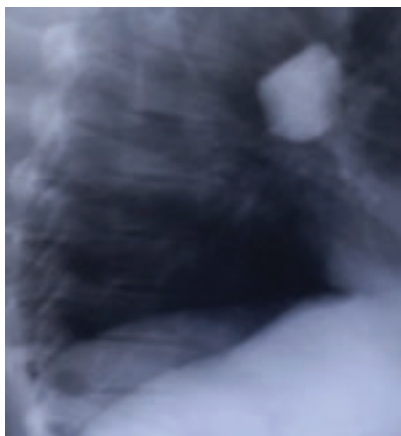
Oblique view Chest X-ray stone impacted in oesophagus
